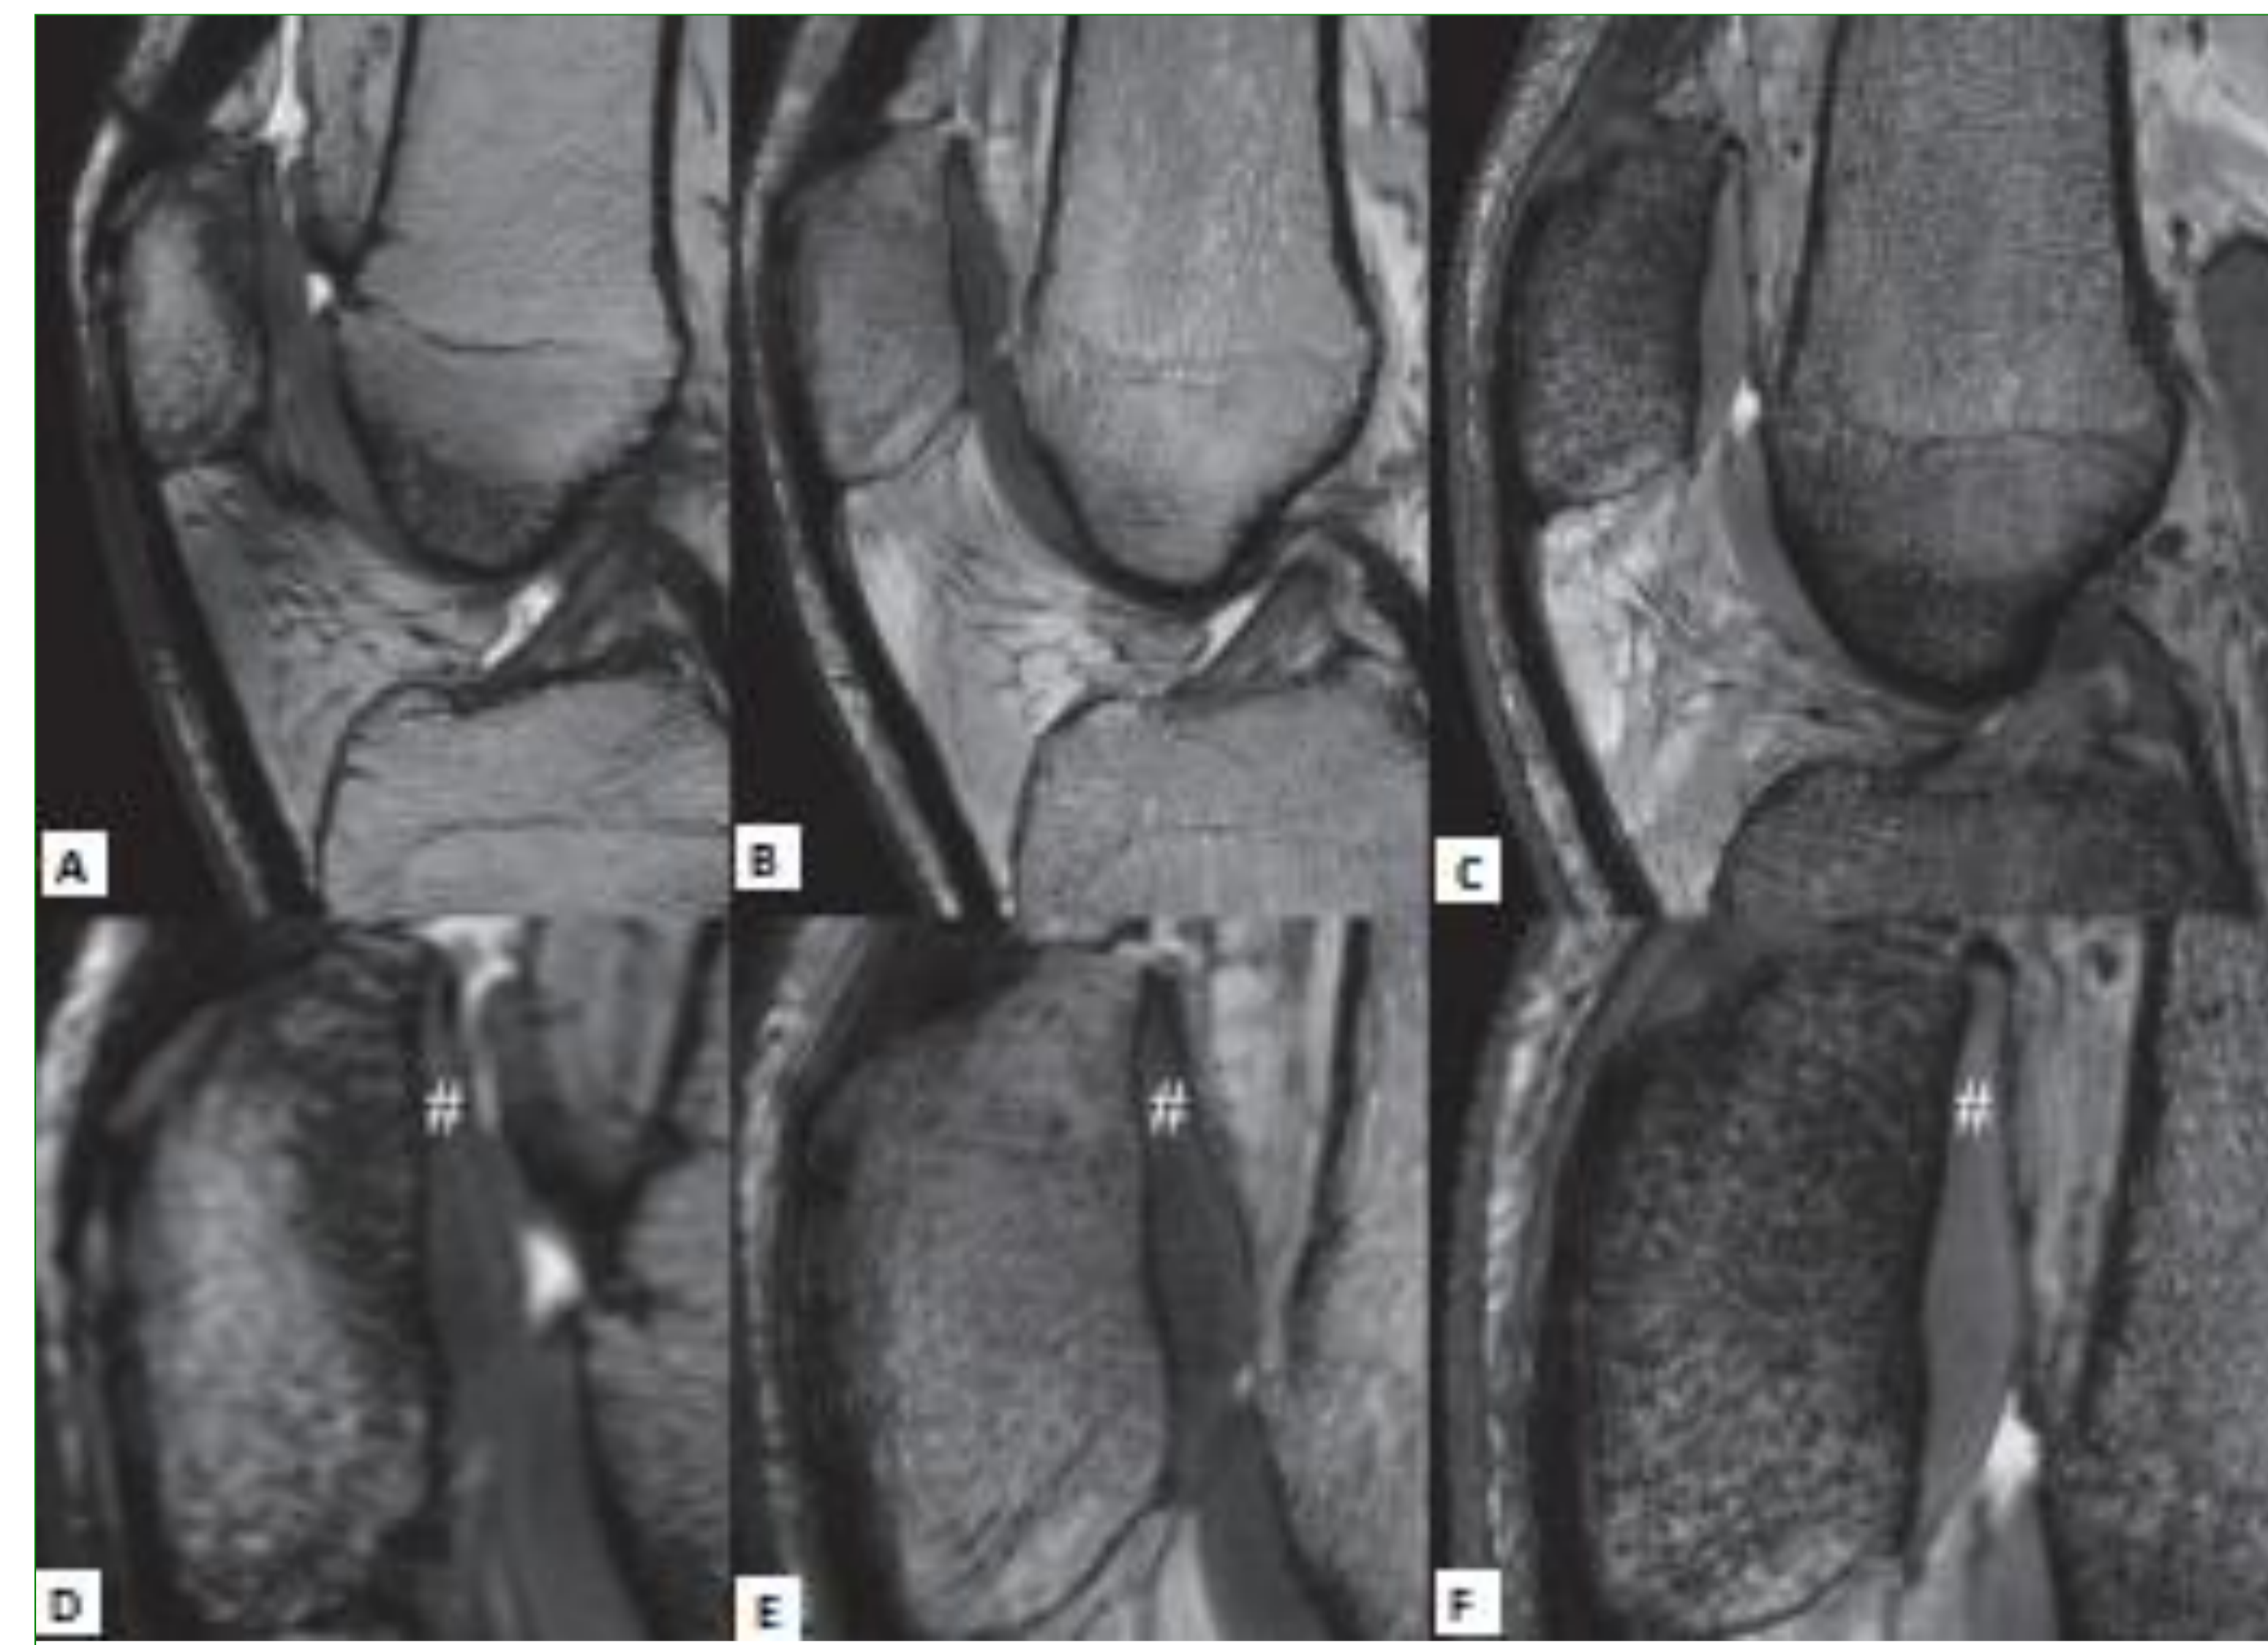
Images A-C show medium field MRI 1.5 T (A), high field MRI 3 T (B), and UHF-MRI 7 T (C) of the knee cartilage in the same 31-year-old male. Comparing the images acquired at increasing field strength, we can observe an improvement in spatial resolution and image detail. Images D-F focus on the patellar cartilage (#) and show a better definition of the borders and a higher spatial resolution obtained at 7 T, with a pixel size of 130 micron (F), in comparison with 1.5 T (D) and 3 T MRI (E).
